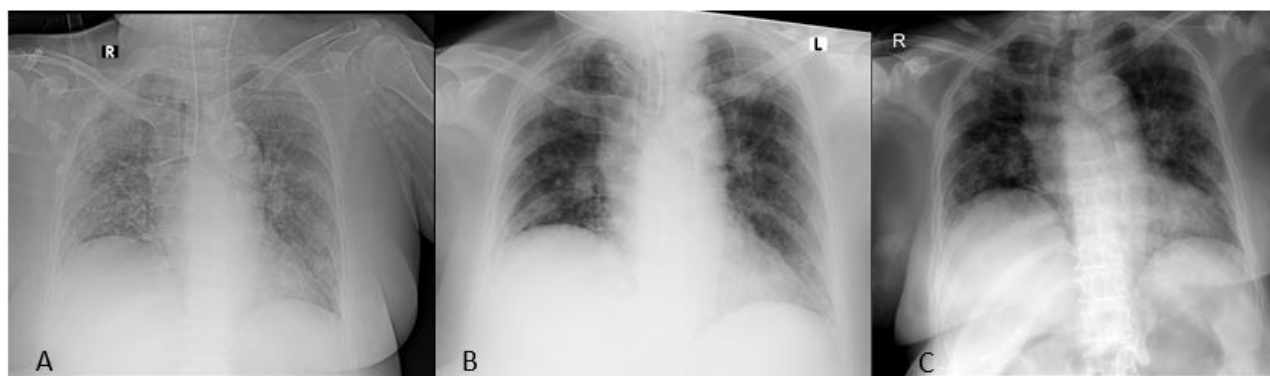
Chest radiograph on day 6/before UC-MSCs therapy (a), on day 15 (b), and on day 24 when the patient was discharged
